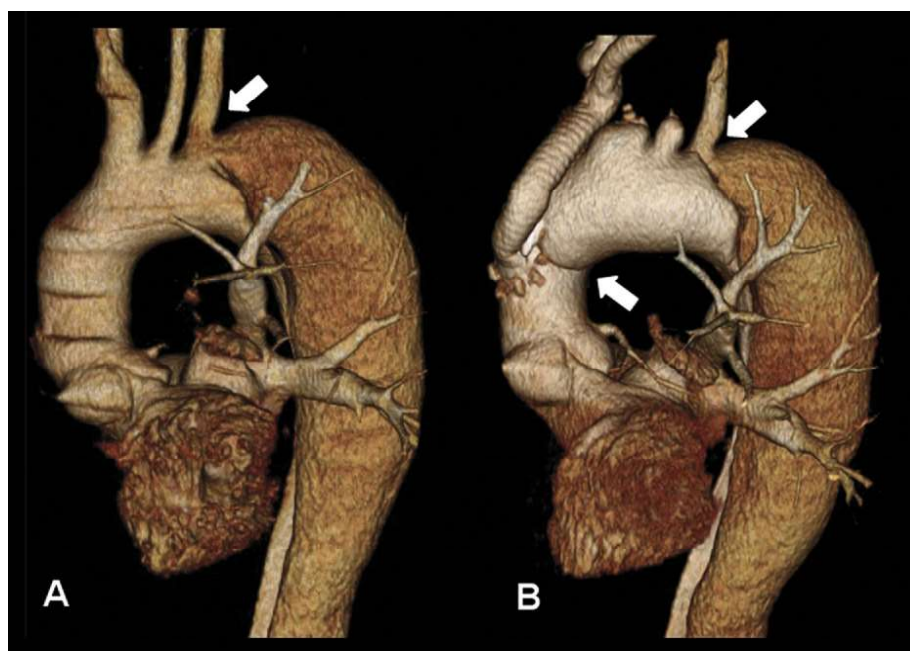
Three-dimensional volume rendering of computed tomography angiographies showing a (A) preoperative chronic expanding aortic dissection type B (*entry tear: white arrow*) and (B) retrograde type A dissection after complete debranching (*white arrows*).
